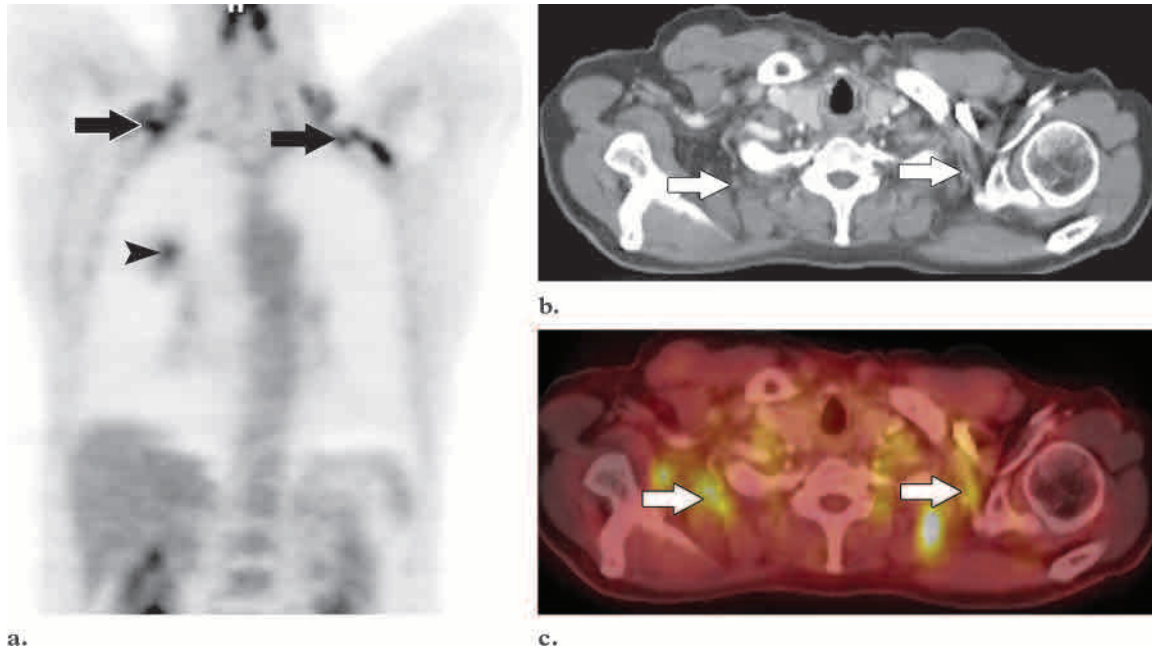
Physiologic muscle uptake. (a) Coronal PET scan demonstrates multiple bilateral foci of intense FDG uptake (arrows). Note also the primary right lung cancer (arrowhead). (b) Axial CT scan of the lower neck shows foci of intense FDG uptake in the shoulder girdle (arrows). (c) Fused PET-CT scan helps localize the foci of FDG uptake to muscles and fat in the shoulder girdle (arrows).
